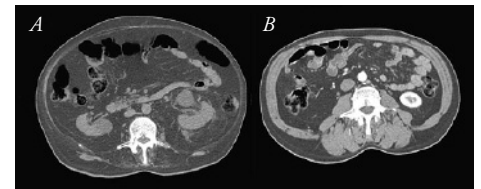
CT images from two male cancer patients with BMI 24.3 kg/m². (A) represents extreme muscle wasting with severe atrophy of the psoas muscle and muscles of the abdominal wall, (B) represents normal body composition. The presence of sarcopenia in (A) is obscured by the replacement with visceral adipose tissue.
